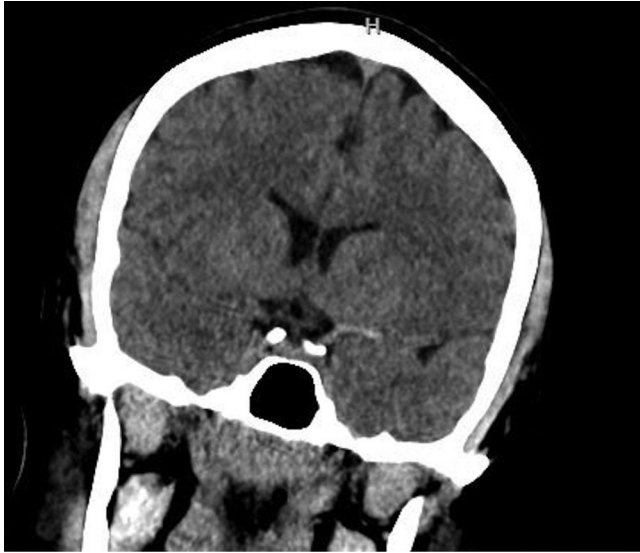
Non-contrasted coronal computed tomography head imaging showing a left hyperdense middle cerebral artery sign.
